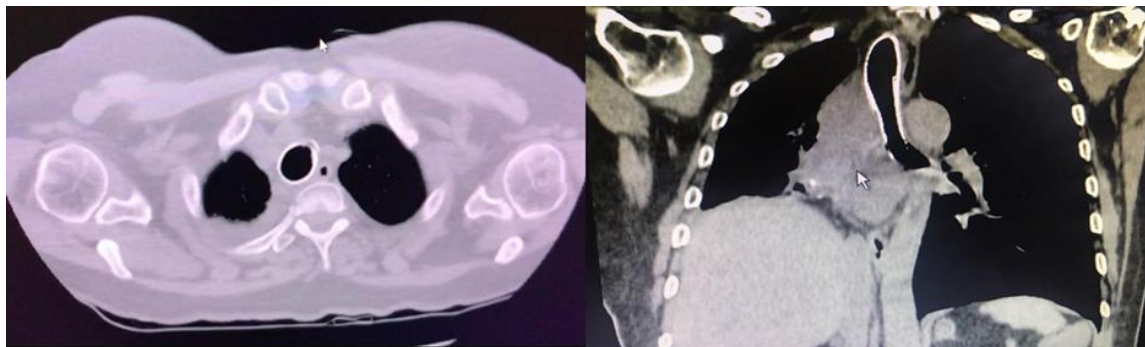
Computed Tomography of thorax after stent placement.
